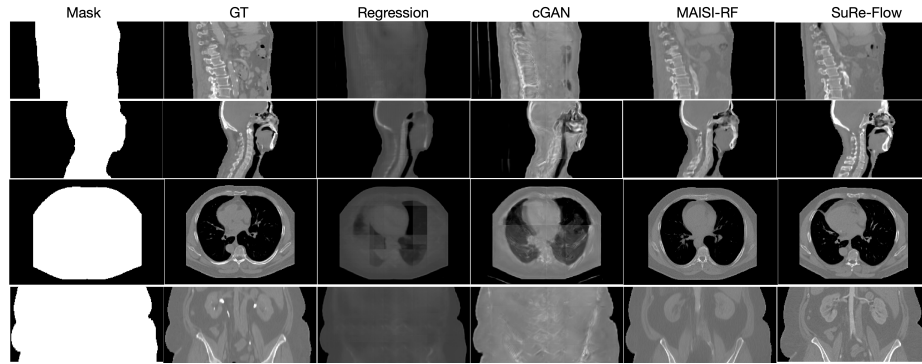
Qualitative comparison of synthetic CT generation across baseline models and SuRe-Flow. SuRe-Flow preserves fine structural details and sharp boundary gradients.
